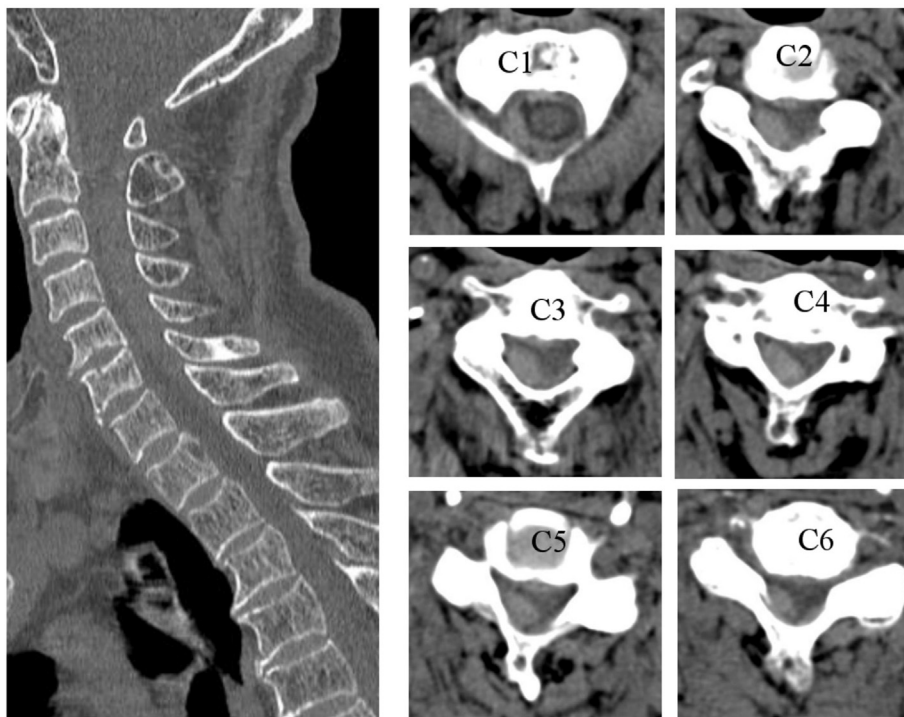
CT showed an isodensity epidural mass over the right dorsal side that compressed the dural sac.
